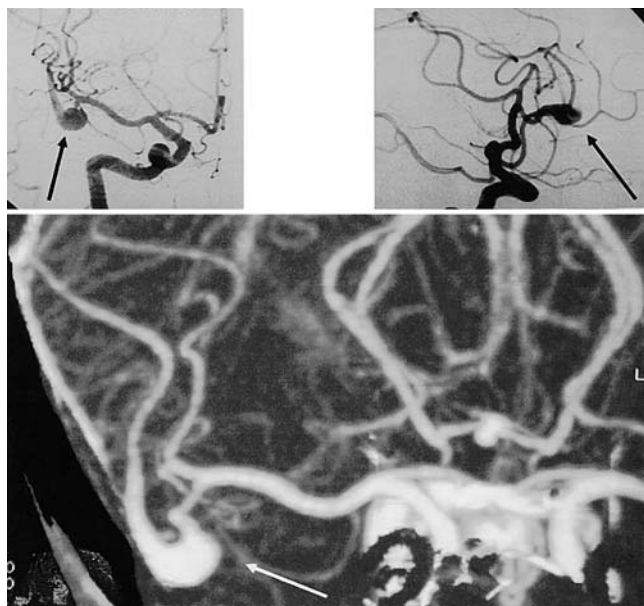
Case 1. *Upper:* Angiograms demonstrating anteroposterior (*left*) and lateral (*right*) views of the right MCA fusiform aneurysm (*arrows*) with its origin just distal to the MCA trifurcation. The distal portion of vessel continues into the posterior aspect of the sylvian fissure. *Lower:* Three-dimensional reconstruction of a CT angiogram detailing the anatomy of the aneurysm (*arrow*).
